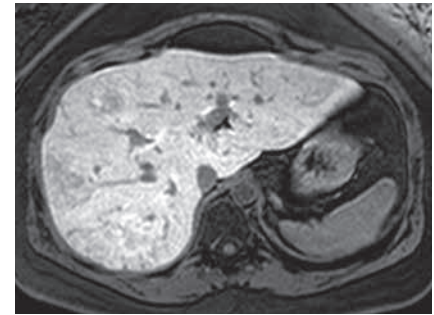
Axial MR image after Primovist® administration shows heterogeneous enhancement of all lesions.
